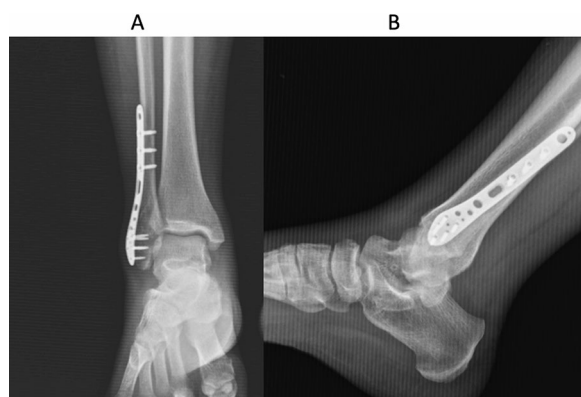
Follow up X-Rays, A: Anterior-Posterior X-ray, B: Lateral X-ray
